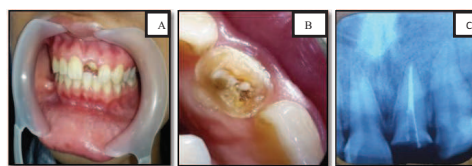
(A) Clinical aspect of fractured left maxillary central incisor (B) Occlusal view of the crown fracture (C) Initial radiographic
